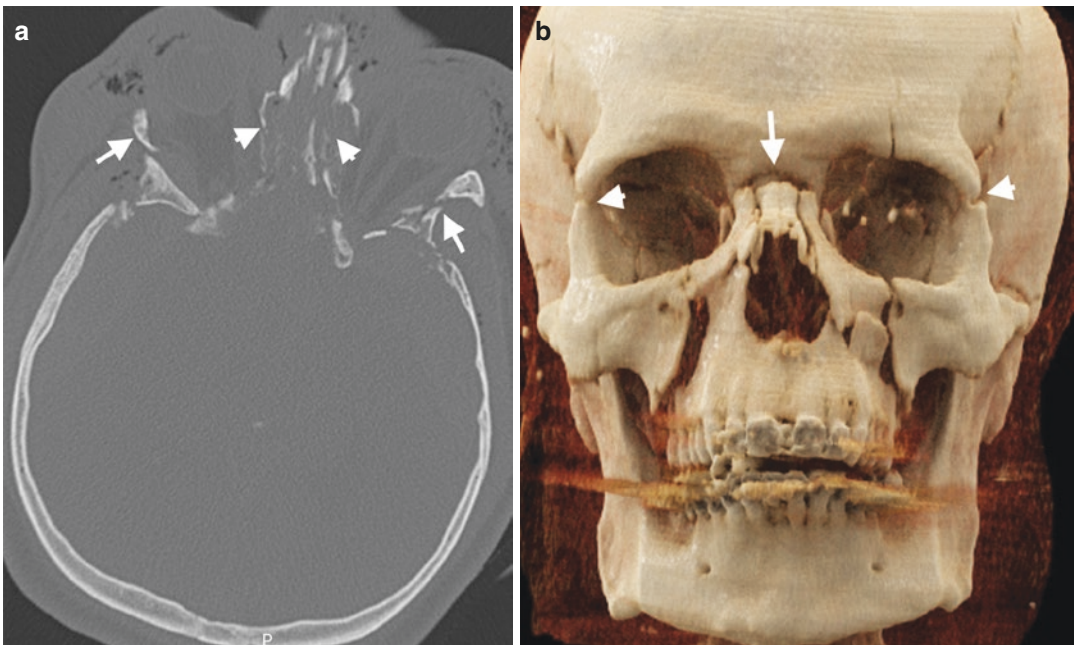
Le Fort III fracture. (a) Axial CT image demonstrates medial (arrowheads) and lateral walls (arrows) fractures of bilateral orbita. (b) CR image shows Le fort III fracture extending through bilateral zygomaticofrontal
